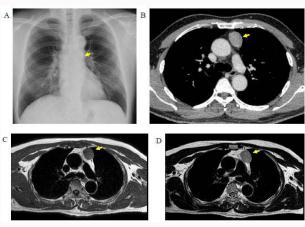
Preoperative Chest X-ray and CT findings showed a solid mass with a clear border in the anterior mediastinum (arrow) (A, B). Chest MRI showed that the tumor had signal characteristics similar to the muscle on T1-weighted images. On T2-weighted images, the signal was higher than the muscle and revealed homogeneous enhancement (C. D).
